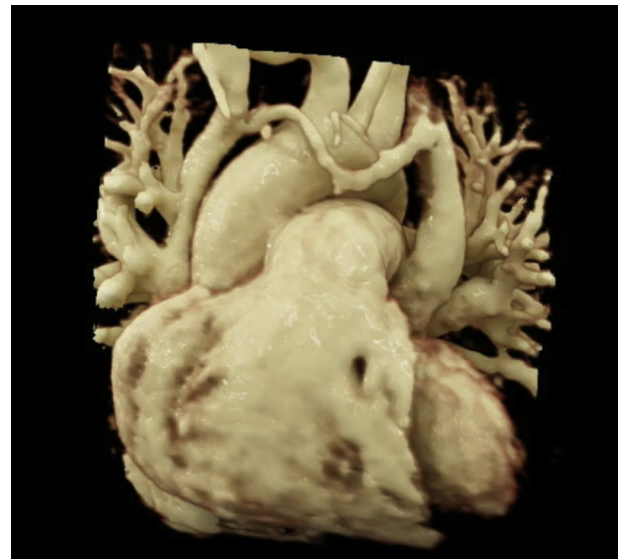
Cardiac magnetic resonance imaging demonstrating venous anomalies.
